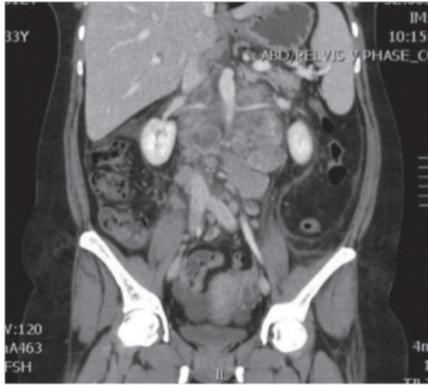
Coronal CT Scan Showing the Retroperitoneal Necrotic Large Lymph Nodes
